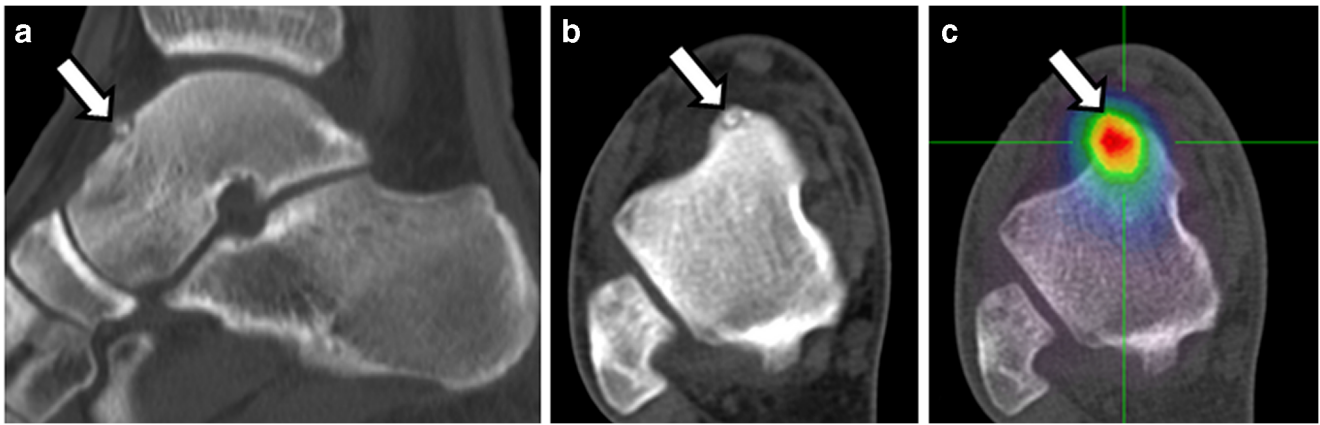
Sagittal (a) and transverse (b) reformatted images of the spiral computed tomography (CT) obtained at the initial presentation show the presence of a small calcified lesion adjacent to the anterior aspect of the articular surface of the talus (talar dome) (arrows). Corresponding
